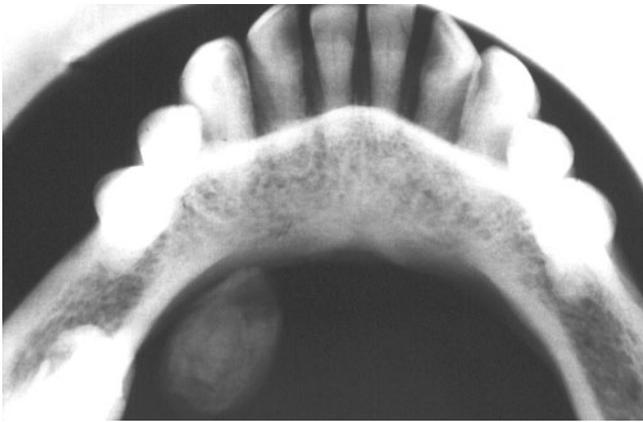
This roentgenogram occlusal view demonstrates a calcified deposit in Wharton's duct.
